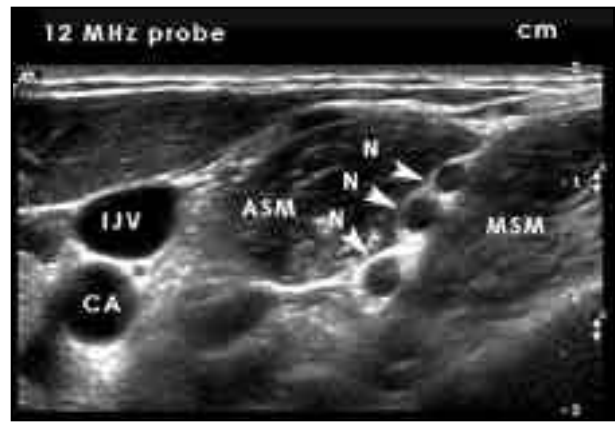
Nerves as seen on Ultrasound scan of Interscalene area
